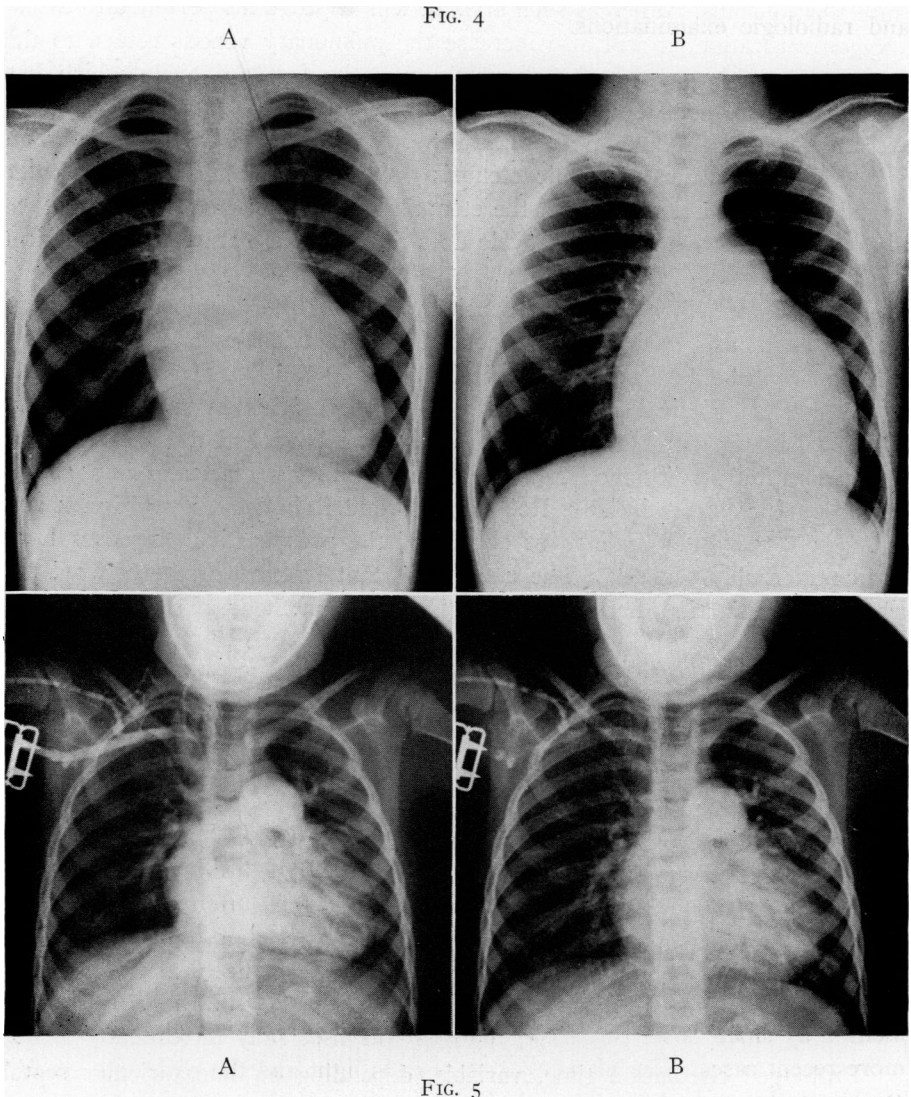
Chest roentgenograms of two patients (J. T. and C. B.) discussed in text—note cardiac enlargement and prominence in region of main pulmonary artery.
